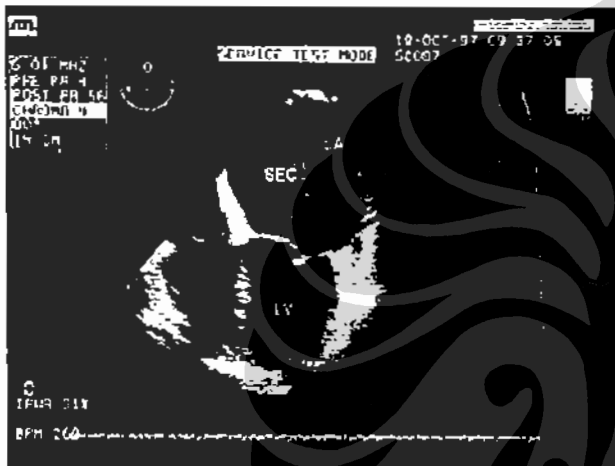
Severe Mitral Stenosis detected by TEE (Trans Esophageal Echocardiography) LA = Left Atrium, LAA = Left Atrial Appendage, LV = Left Ventricular SEC = Spontaneous Echo Contrast
